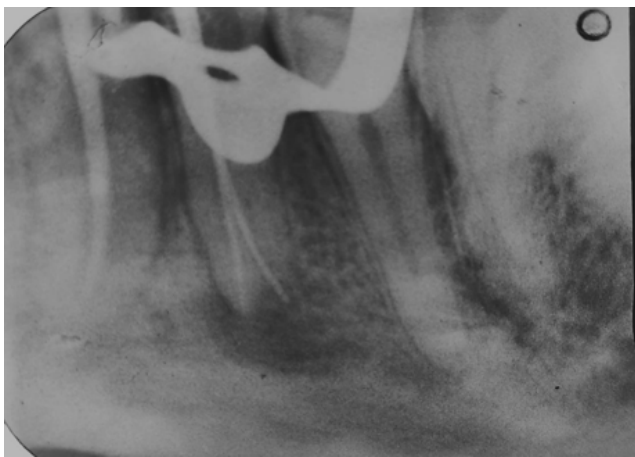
Radiograph of right mandibular 1st premolar (Master cone)
